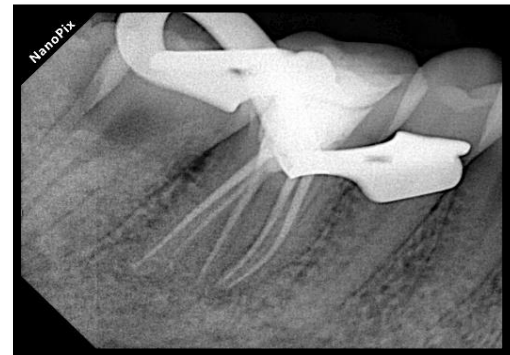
Post-obturation radiographs
